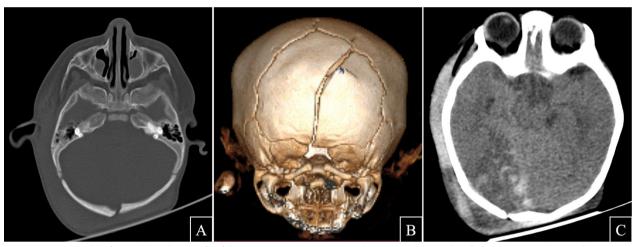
A 9-month-old infant with head injury after fall—Non-Contrast CT scan a axial image in bone window, b VRT image reveals partially displaced fracture in the occipital bone extending up to foramen magnum and right parietal bone. c Axial image in brain window shows haemorrhagic contusion in right parietooccipital region along with heterogeneous swelling in scalp in occipital region
